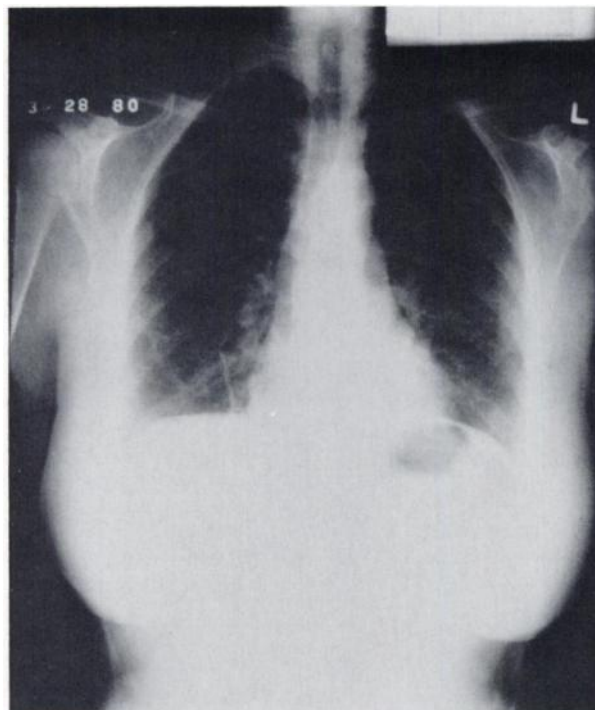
Admission radiograph showing reticulonodular infiltrates in lower lung fields.
